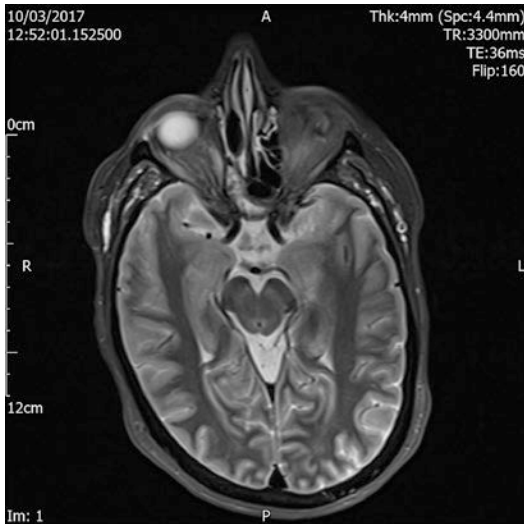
Postoperative axial MRI scan of the paranasal sinuses demonstrating a clear right ethmoidal complex and right orbit. There is some mucosal thickening of the right sphenoidal recess but no evidence of recurrent disease
